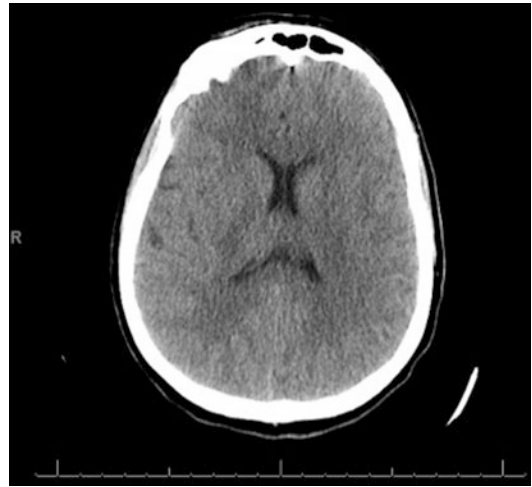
Non-contrast head CT at hospital day 2. The scan demonstrates evidence of diffuse cerebral edema with loss of the grey-white junction and reduced sulcal folds throughout
